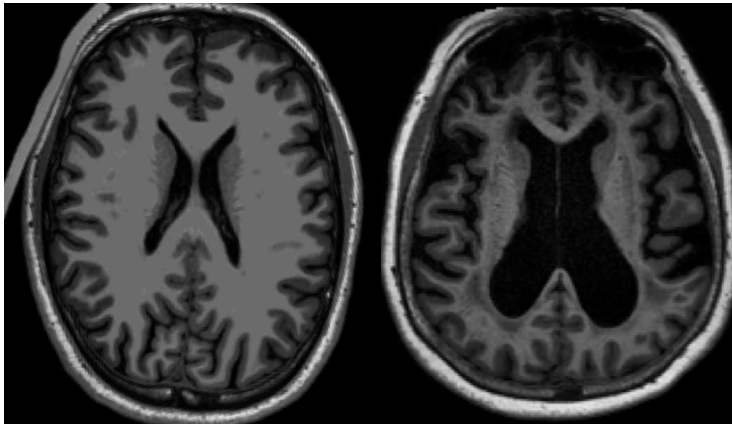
Axial slice from  $T_1$ -weighted MRI of a healthy control (left, MRI publicly available at [107]) and iNPH (right, subject from the study [159]) showing enlarged ventricles.
